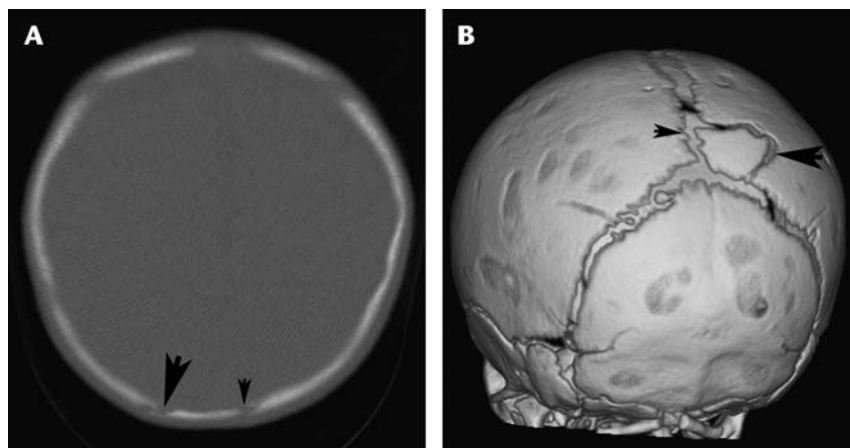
A, A 6-week-old child was evaluated after admitted abuse by his mother. CT suggested a right posterior parietal fracture (large arrow) near the sagittal suture (small arrow). B, 3-D CT demonstrated a large posterior parietal sutural bone (arrows) instead of a fracture.
